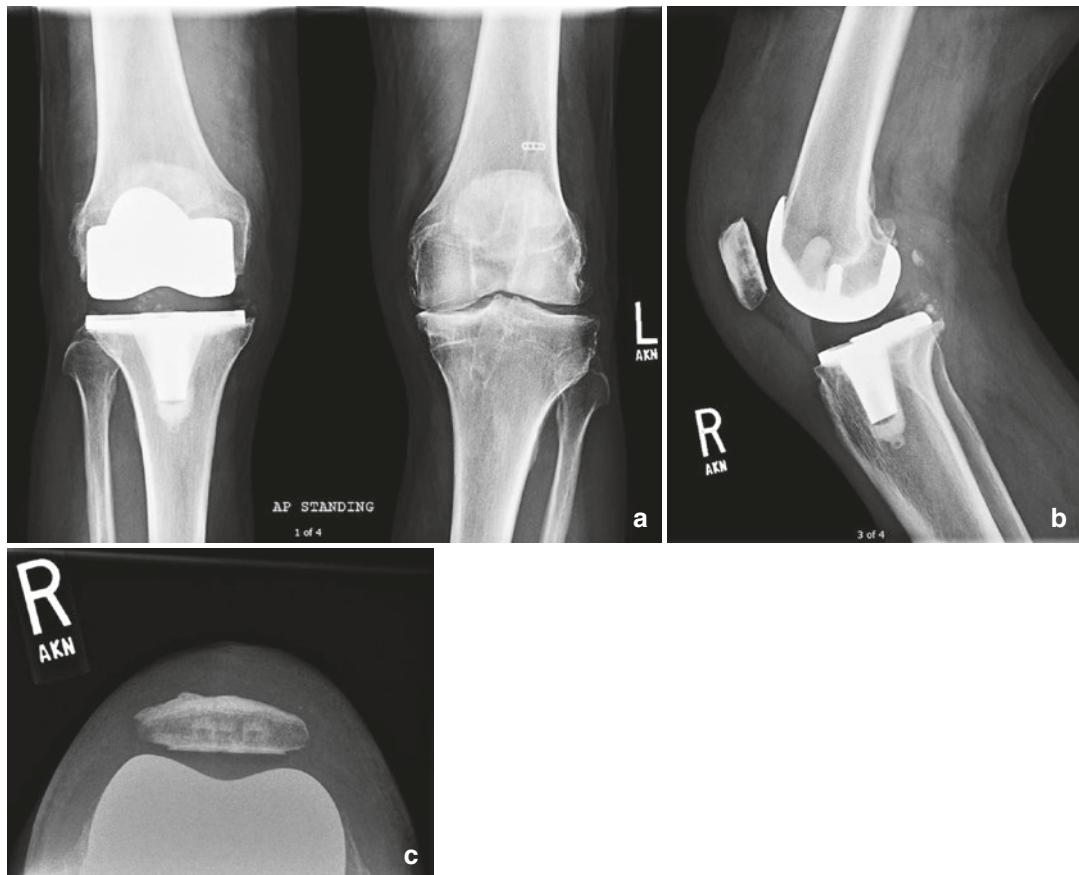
One-month postoperative (a) anteroposterior, (b) lateral, and (c) sunrise radiographs demonstrate well-fixed right total knee arthroplasty
